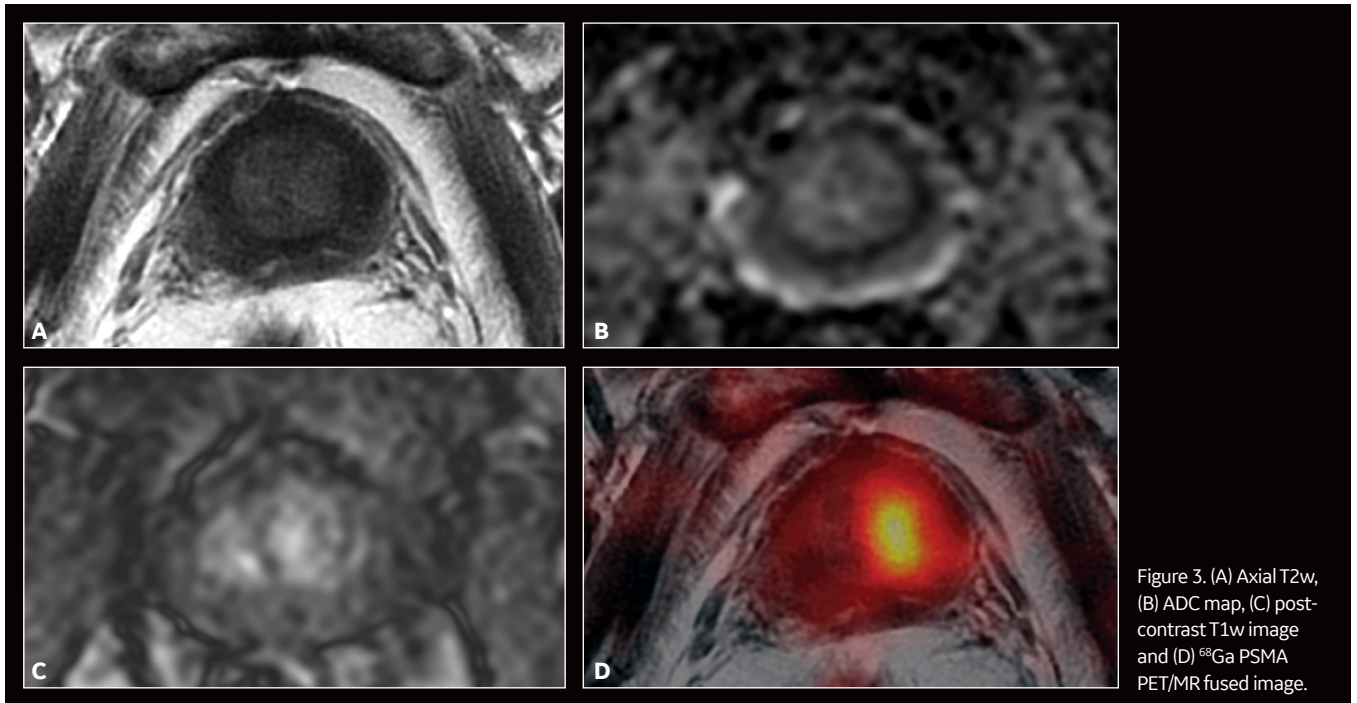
(A) Axial T2w, (B) ADC map, (C) post-contrast T1w image and (D) ^{68}Ga PSMA PET/MR fused image.
